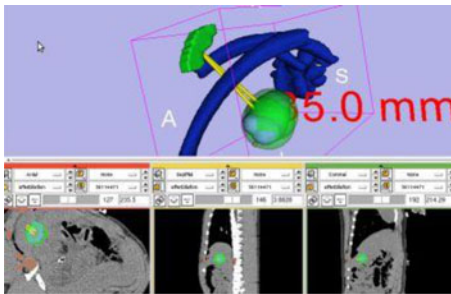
Treatment plan visualization module for surgeons to evaluate the plan before execution. The long axis is approximately 35 mm calculated by Slicer's measurement module ([www.slicer.org](http://www.slicer.org)). The planned ablation spheres were overlaid onto the preoperative CT images as shown in the three lower slice views, which make it easy to examine slice-by-slice performance. (Refer to the web version of this paper for the color figure.)
